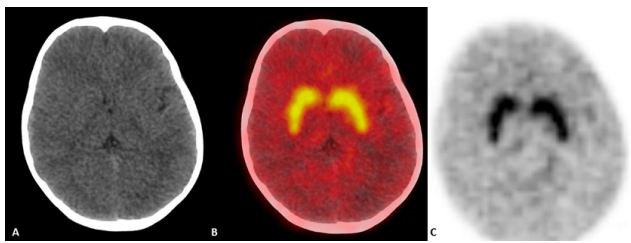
F-DOPA PET CT, Plain CT showing striatal structures; A: Fusion PET CT showing normal dopaminergic activity in striatum; B: Dedicated DOPA Brain PET image; C: showing normal dopaminergic activity in striatum.
